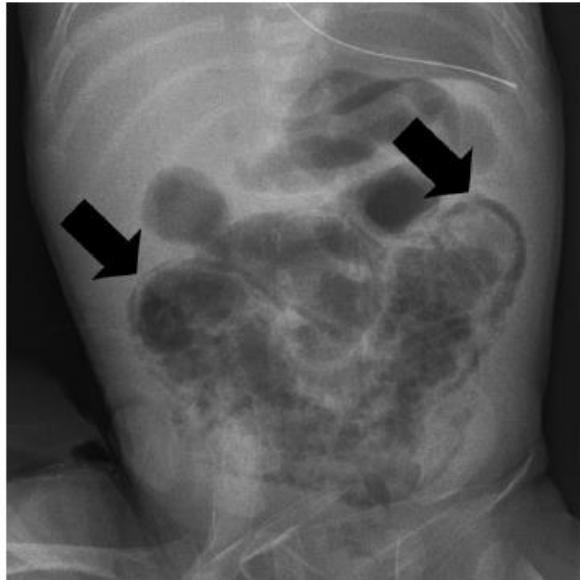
Abdominal X-ray picture showing extensive pneumatosis intestinalis (arrows) in the H-ficolin-deficient patient at onset of necrotising enterocolitis.
